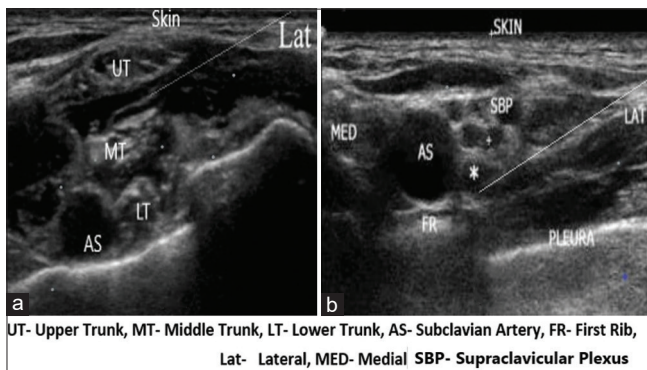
(a) Ultrasonography image of the IT approach of SCB after injection of LA in two IT planes. (b) Ultrasonography image of CP approach of SCB showing point (*) of LA deposition. CP = corner pocket, SCB = supraclavicular block, IT = intertruncal, LA = local anaesthetic
